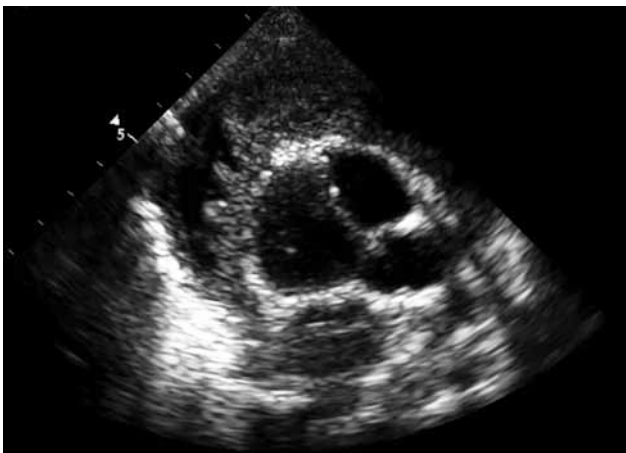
Echocardiography showing the fibrinous pericardial effusion.
